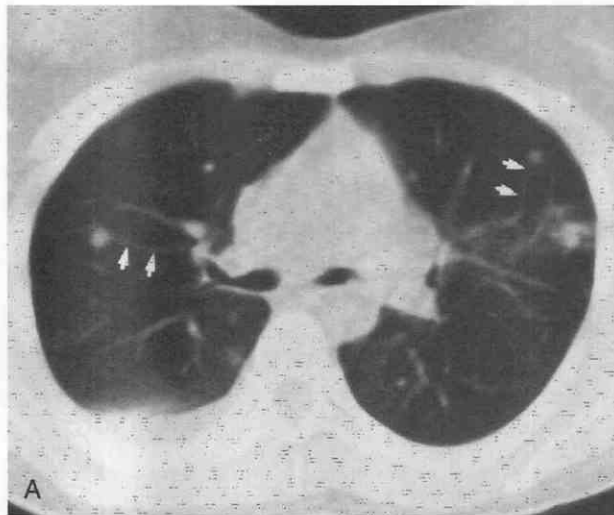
CT findings of Wegener's granulomatosis. A, Multiple nodules with feeding vessels (arrows). (From Kuhlman JE, Hruban RH, Fishman EK: Wegener granulomatosis: CT features of parenchymal lung disease. *J Comput Assist Tomog* 15:948-952, 1991.) B, Two pleura-based lesions (large arrows) resembling infarcts, and several smaller peripheral nodules (small arrows). C, Patient with long-standing Wegener's granulomatosis under treatment. Scarring, spiculation, and pleural reaction can be seen around peripheral pulmonary nodules (arrows).
